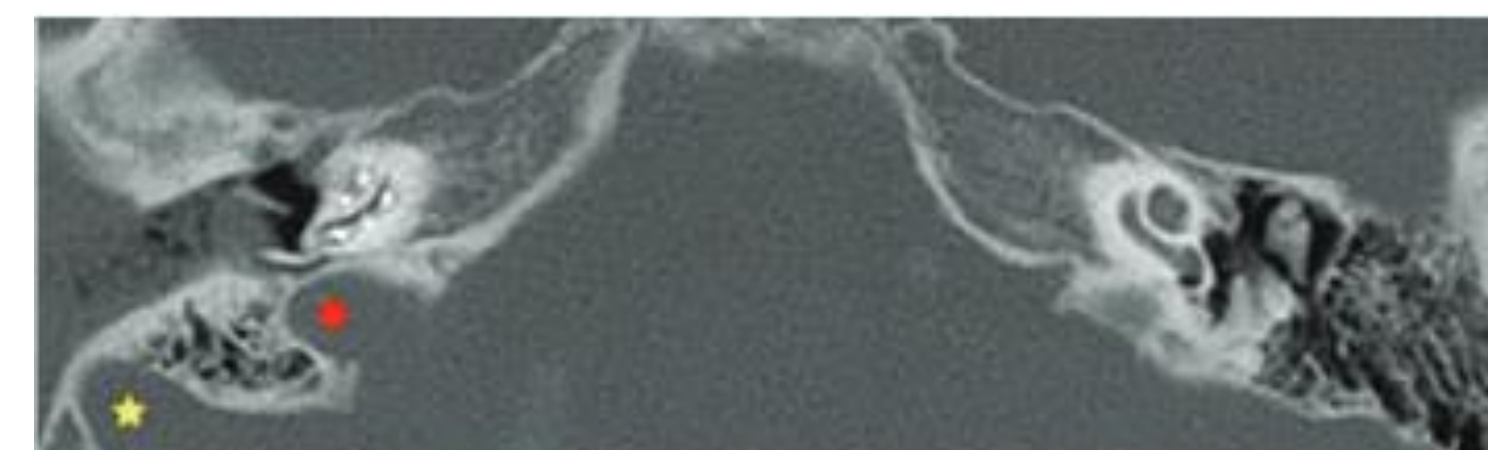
HRCT of the temporal bones performed after surgery to verify the position of the implant electrode.. Also visible is significant protruding of the sigmoid sinus (yellow asterisk), a small hypoplastic mastoid process, and an extensive jugular vein bulb (red asterisk).
